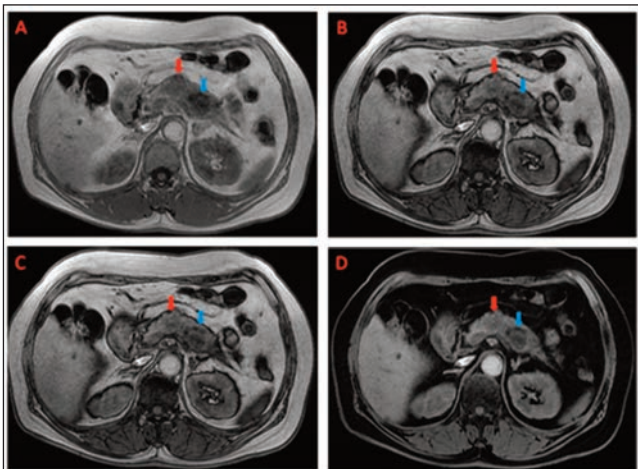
(A) Magnetic resonance imaging of in-phase; (B) out of phase ; (C) LAVA fat image; and (D) LAVA water image are shown. The nodular shadow in the neck of the pancreas was 2.3×2.1cm (red arrow), while another nodule in the body/tail was 2.5×2.2cm (blue arrow), with a slightly dilated pancreatic duct.
